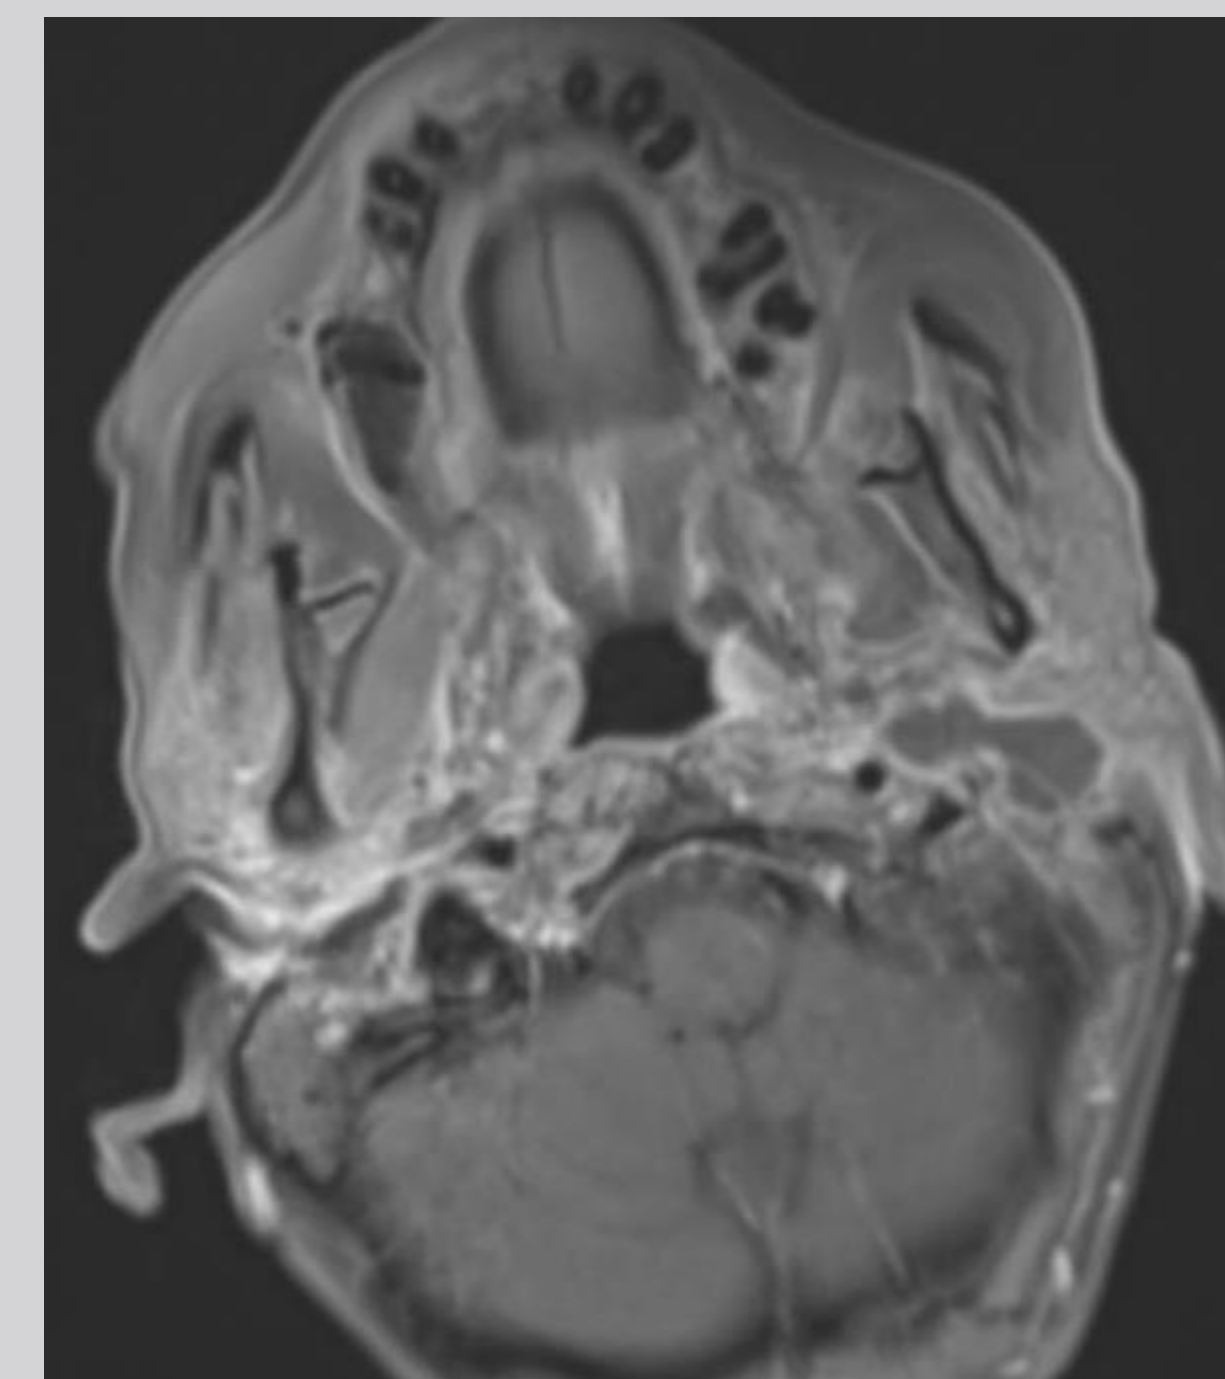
MRI neck of the patient in Case 2 demonstrating a 2.5cm left parapharyngeal space abscess.
